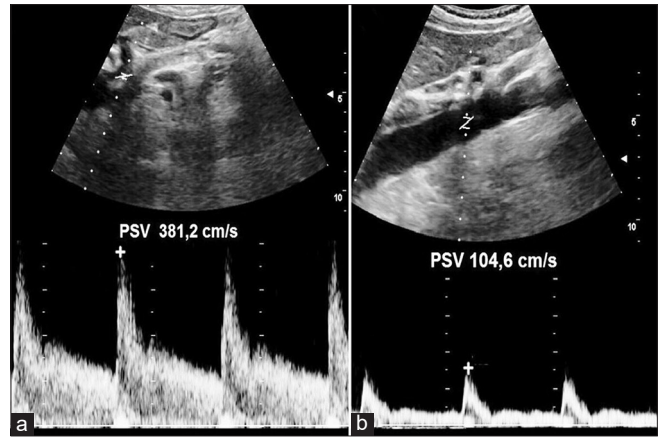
Ultrasound findings of DS. The flow ratio measurement is obtained from ratio between PSV of CA, measured in stenotic tract in expiratory apnea (a) and PSV of abdominal aorta measured at CA origin level (b). DS: Dunbar syndrome, CA: Celiac artery, PSV: Peak speed velocity
